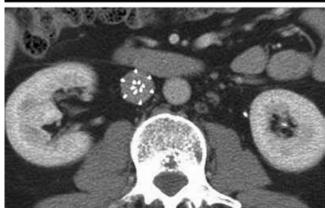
Follow-up transverse contrast material—enhanced spiral computed tomographic (CT) scan obtained as part of this patient's routine medical care 2 weeks after placement of an RNF shows the filter to be in good position, with no associated complication.
